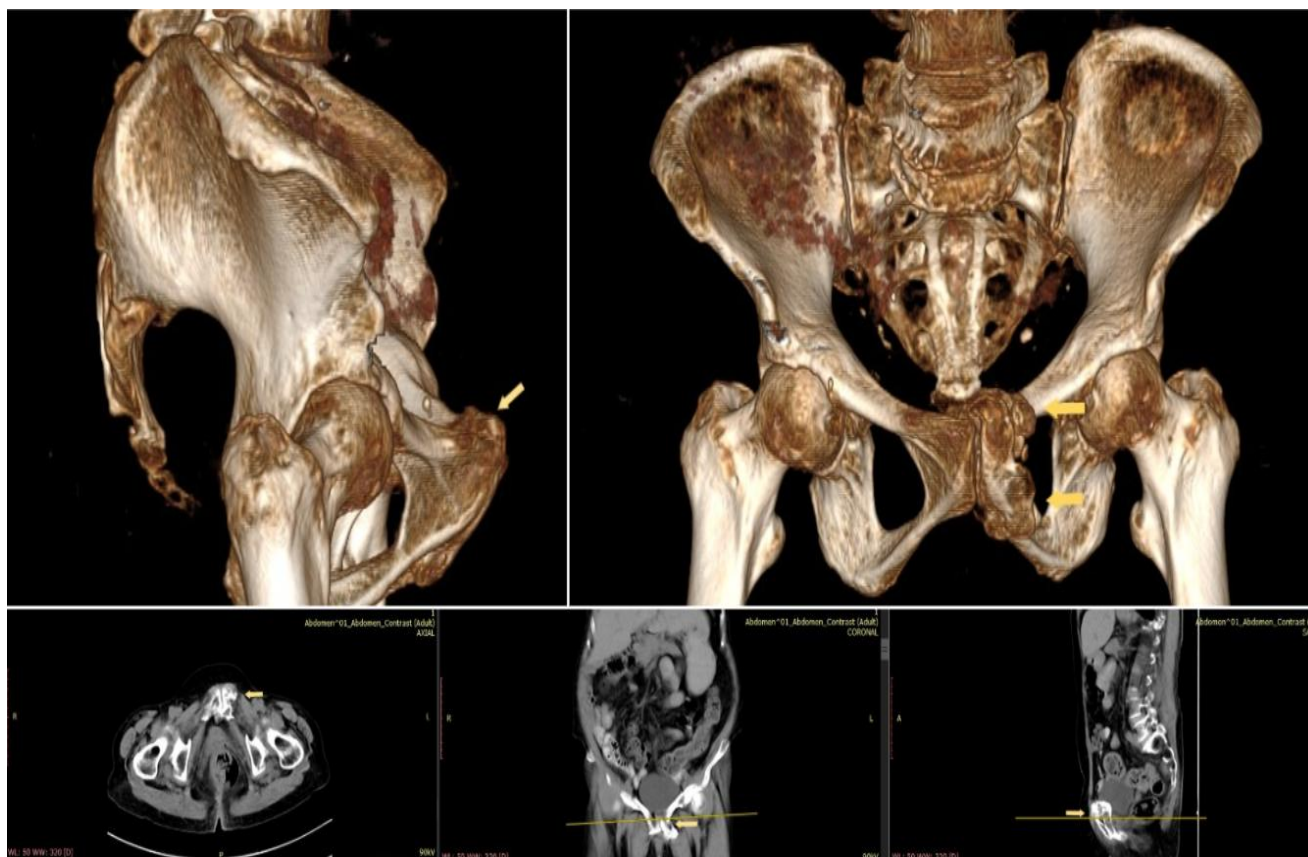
CT scan of the pelvic region revealed old fractures of the left superior and inferior pubic rami.
